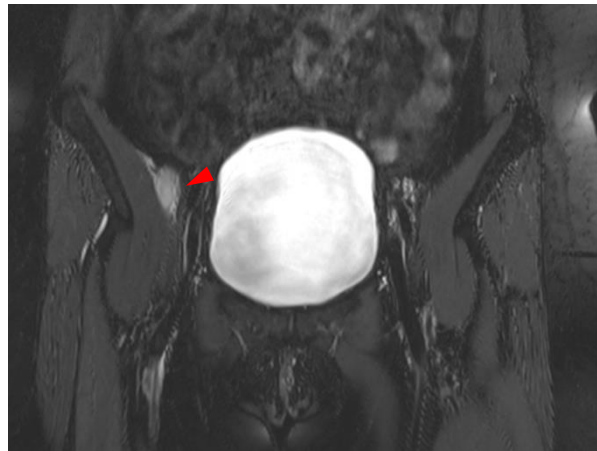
Coronal T2-weighted SPACE STIR MR images of the pelvis optimized for neurography (red arrow head)
